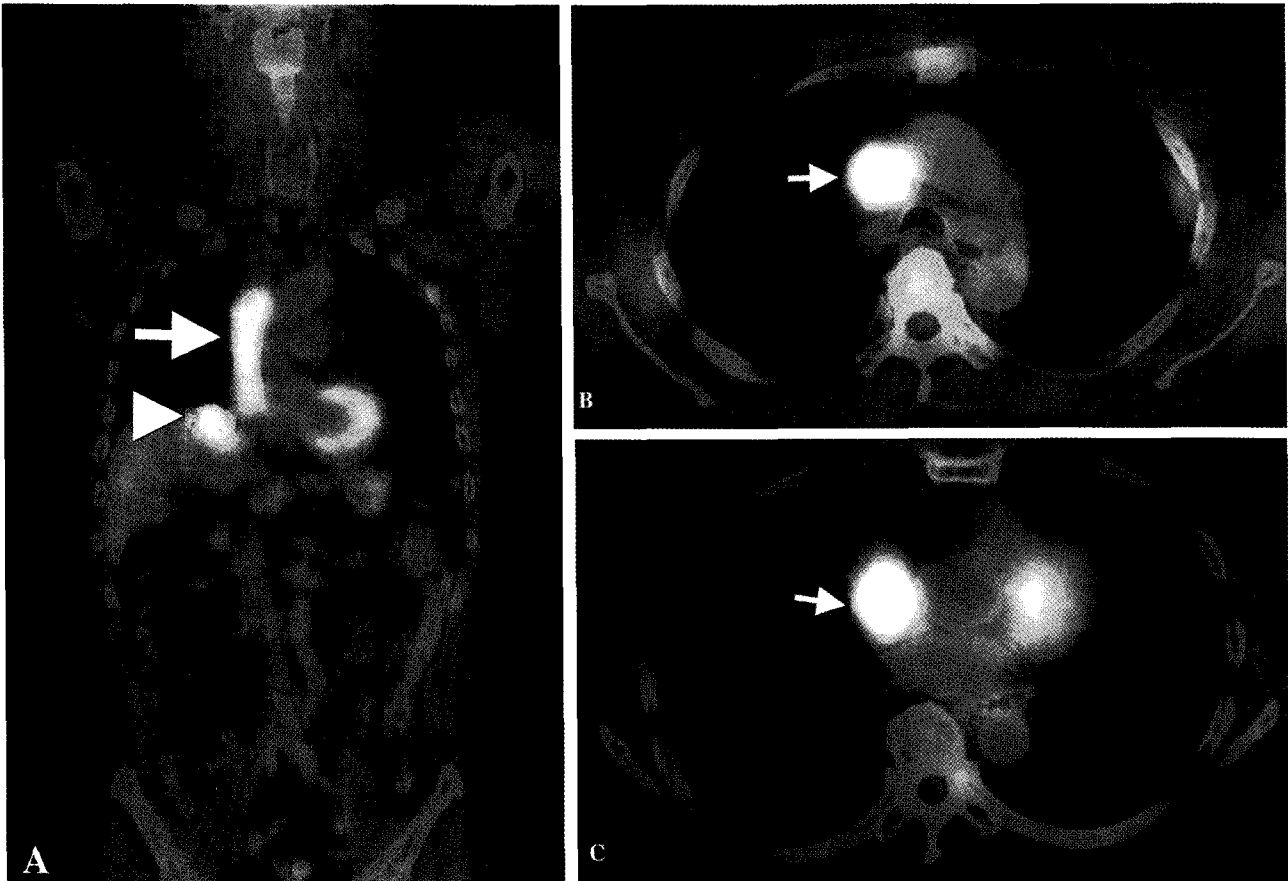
(A) The coronal image of F-18 FDG PET/CT showed increased FDG uptake in tumor thrombus (arrow) involving from SVC extending to right atrium. And, there was increased metabolic activity in residual viable tumor in dome of liver (arrowhead). (B) The axial image of F-18 FDG PET/CT showed intense FDG uptake in the SVC (max SUV= 5.72) (arrow). (C) The axial image of F-18 FDG PET/CT showed intense FDG uptake in the right atrium (max SUV=6.98) (arrow)
